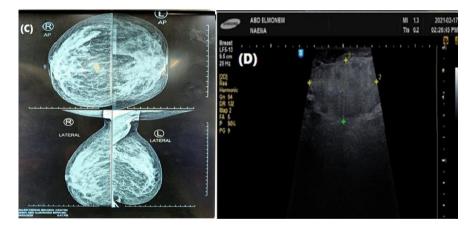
Radiological evaluation after 6 months. Mammography (left) demonstrates likely benign findings in the form of architectural distortion, but the ultrasound scanning (right) was performed due to a palpable mass showing areas of fat necrosis with tiny oil cysts
